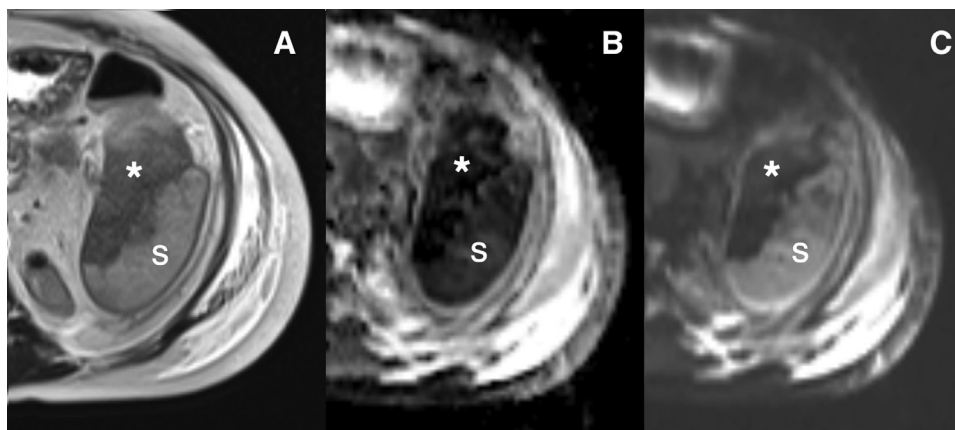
Splenic infarcts on MRI. Axial T2 weighted (A), ADC map (B), and DWI (C) sequences at the level of the mid-abdomen. The normal viable splenic tissue (s) is mildly T2 hyperintense and mildly restricts diffusion, similar in signal as nodal tissue. Infarcted spleen (*) is hypointense on all 3 sequences. The normal restricted diffusion of the spleen should not be confused as infection or other pathology.
